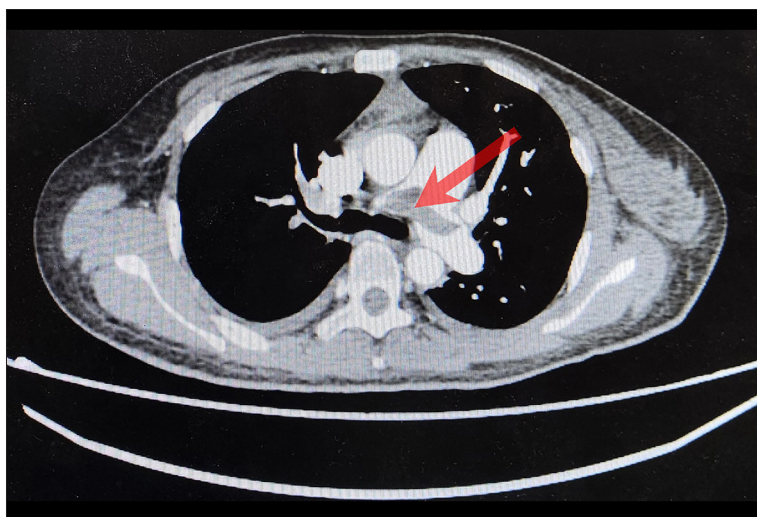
Axial CT pulmonary angiography showing a large filling defect occluding the right pulmonary artery main trunk with absent distal opacification (red arrow). Abbreviations: CT, computed tomography.
